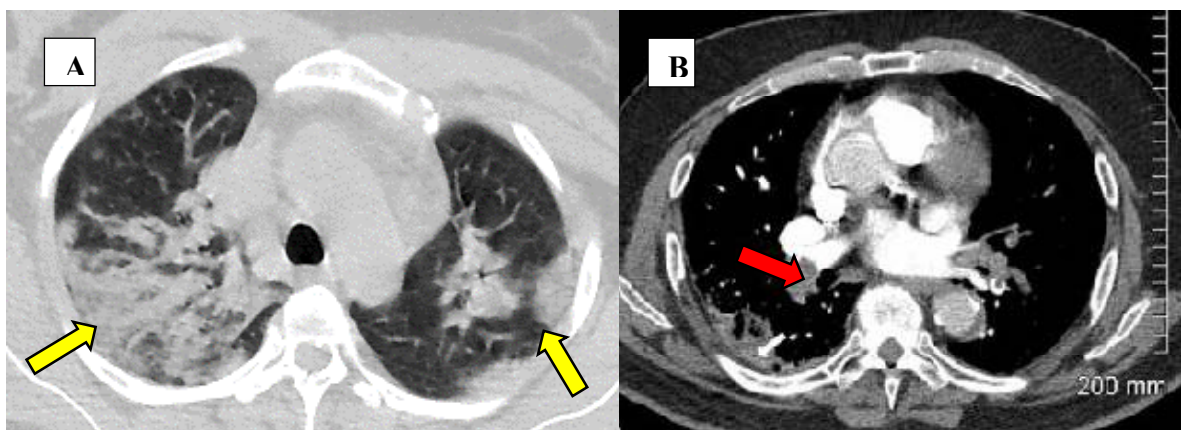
(A) Shows HRCT-Chest of a 48-year-old male with confluent areas of ground glass opacity (yellow arrows) in bilateral upper lobes (admitted in the ICU with severe COVID-19 pneumonia) (B) Shows CTPA in the axial plane with a large filling defect in the right pulmonary artery (red arrow) with resultant opacification (white arrow) representing wedge shaped pulmonary infarct of the right lower lobe.
